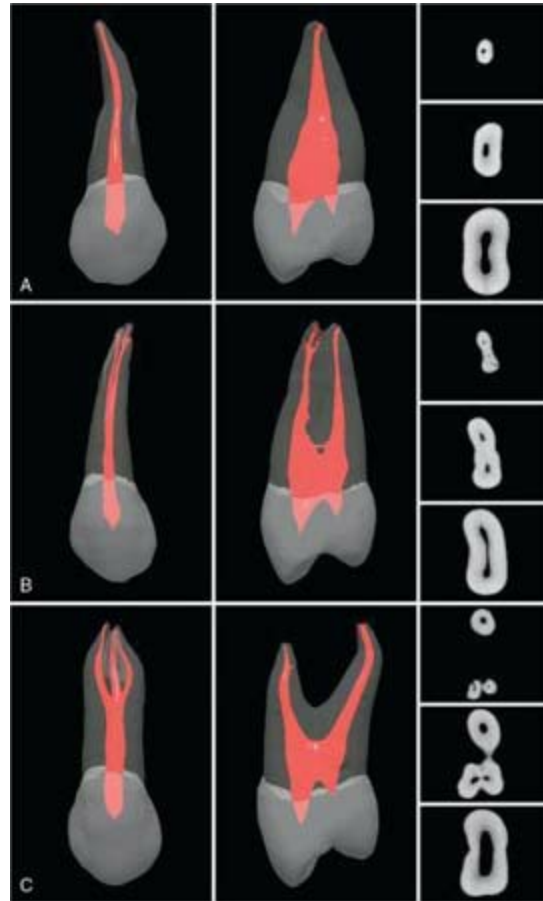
μ CT scans of maxillary second premolars. A, Common anatomic presentation showing one canal. B, Second premolar with two canals and an apical delta. C, Second premolar with three roots/canals that divide at the junction of the middle and apical third of the main root. All teeth are shown from both a buccal (vestibular) and a proximal perspective, along with the cross-sectional anatomy at the coronal, middle, and apical levels. (See Video 7.7 online at the Expert Consult site for rotational views of these teeth.)
